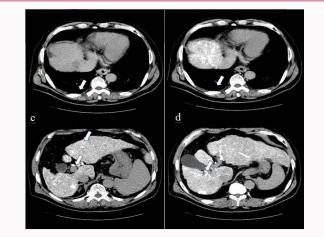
CTA, CTAP. Low density area in CTAP (a) and slight enhancement in CTA (b) were observed in S8 near the IVC, and there were multiple enhancement lesions near S3, S6, and S7 (c,d).
